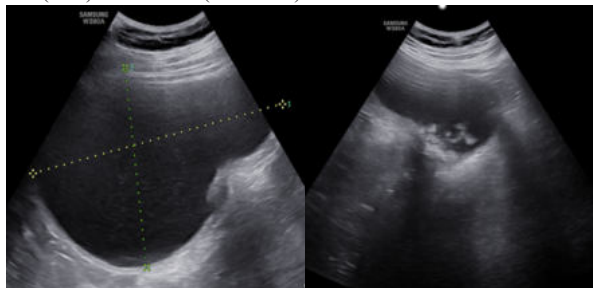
Ultrasound images showing a large cystic lesion measuring 15.6 x 10.7 x 14.8cm in the left adnexa with eccentric echogenic area (1:A) and posterior acoustic shadowing (1:B)
